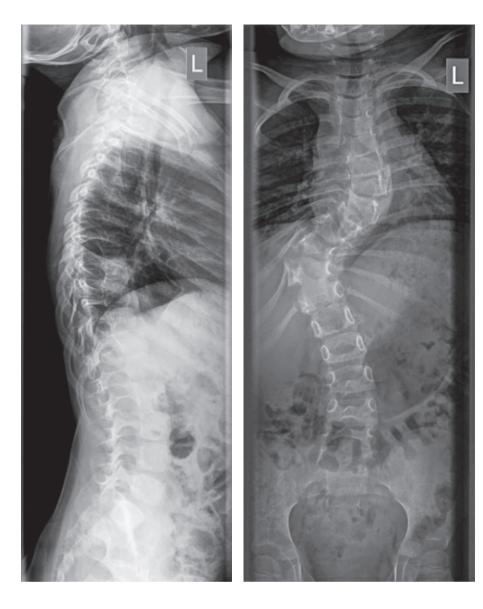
Standing AP and lateral spine x-rays
